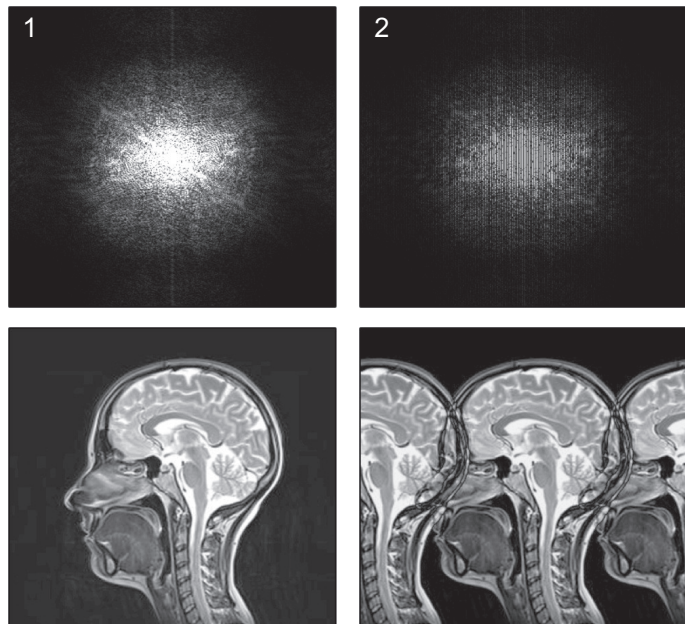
Raw k -space data (upper panels) and the reconstructed MR images (lower panels). The left-hand side shows a completely sampled k -space (1) and the resulting image. On the right, k -space was subsampled by factor of two in one direction (2), which results in aliasing artifacts in the image.*
